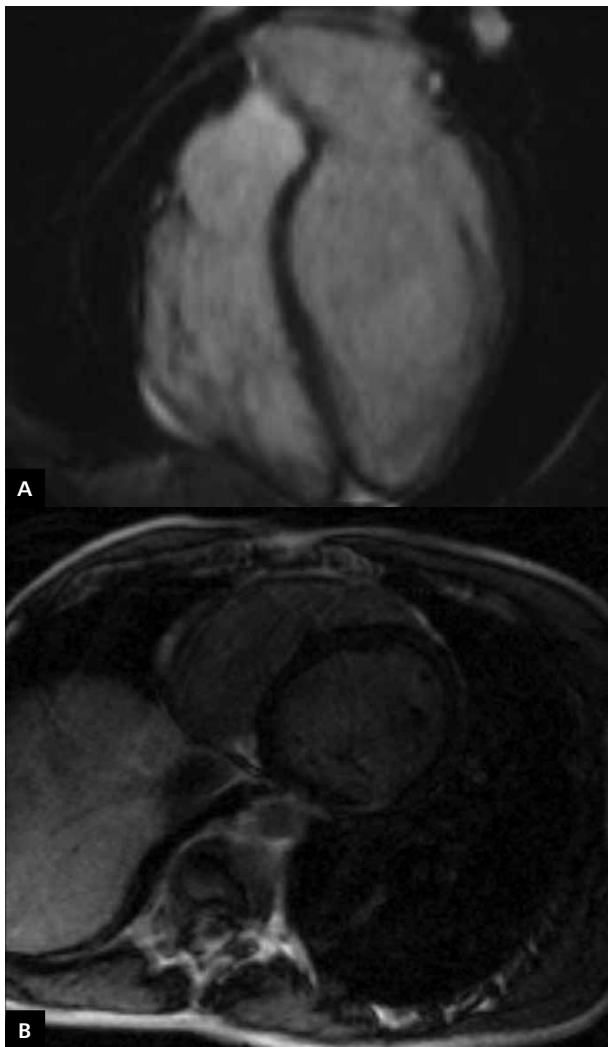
Cardiac magnetic resonance images in a patient with post-inflammatory dilated cardiomyopathy; A. Four-chamber view, cine SSFP sequence. Enlarged left ventricle; B. Short-axis view, cine SSFP sequence. The image of late gadolinium enhancement (visible sub-epicardial fibrosis in the inferior wall suggestive of post-inflammatory aetiology)
